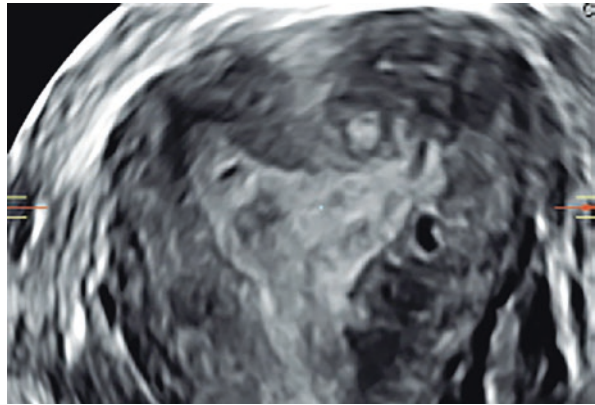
(a, b) Ultrasound images of focal adenomyosis of the JZ. (a) 2D and power Doppler. (b) 3D coronal view, note the buds and cystic areas inside the JZ
